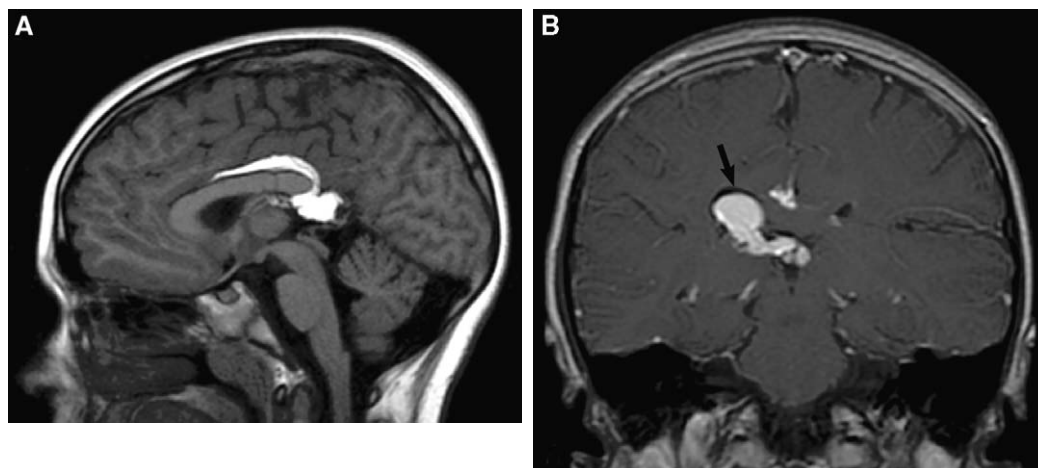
Interhemispheric lipoma. (A) Sagittal T1-weighted image shows a hyperintense lesion surrounding a minimally hypogenetic corpus callosum (absent splenium). (B) Coronal T1-weighted postcontrast image demonstrates intraventricular extension (arrow), a common finding.
